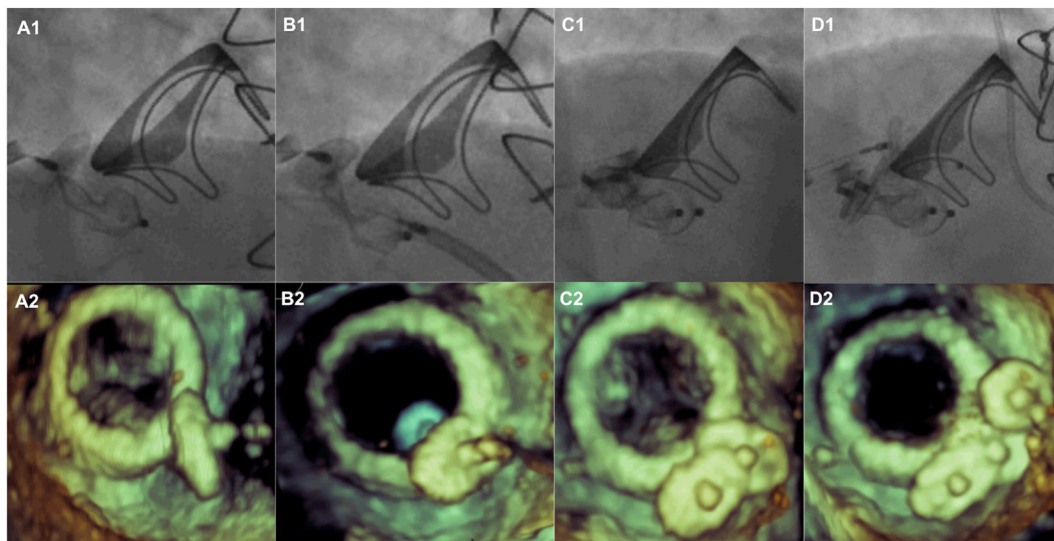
Auto-orientation of Amplatzer PVL plug. Mitral paravalvular leak closed with a first Amplatzer PVL plug under combined fluoroscopic (A1) and three-dimensional echocardiographic (A2) guidance. The plug auto-orientes to the long axis (B1,B2) of the circumferential crescentic leak. A second rectangular Amplatzer PVL plug (C1,C2) and a circular plug (D1,D2) added later complete the transcatheter closure.
